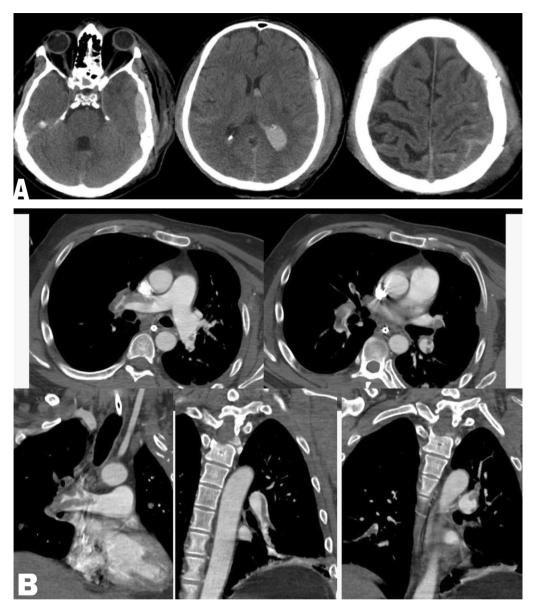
25-year-old male with a history of polytrauma A non-contrast axial CT brain shows left temporo-parietal epidural hematoma with underlying fracture, intra-ventricular hemorrhage, and left side subarachnoid hemorrhage. B Contrast CT chest PE study axial and coronal revealed massive pulmonary embolism on both sides involving both main arteries and segmental branches; the patient was hemodynamically unstable; IV thrombolysis and anticoagulation are contraindicated. C Doppler study shows total thrombosis in the popliteal vein. D Pulmonary angiography confirmed the previous CT finding. E Angiojet catheter is inserted. F PMT was done and recanalization of occluded arteries was noted, and we obtained clinical success, which was defined as resolution of hypoxemia, restoration of hemodynamic stability, and survival. G IVC filter are inserted
